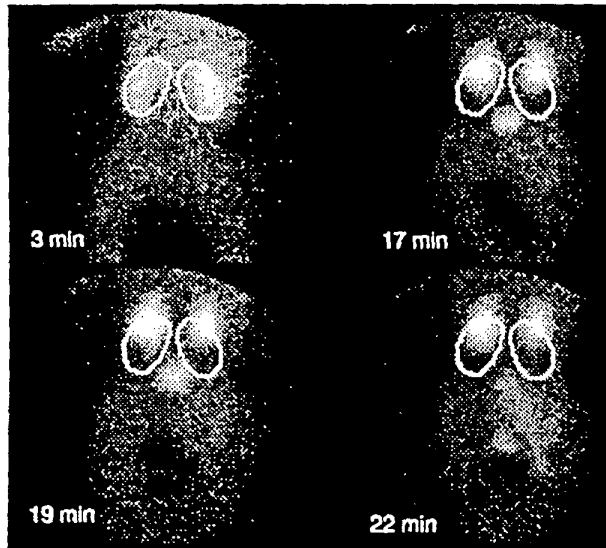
Renal scintigraphic images with superimposed ROIs, showing the effect of patient motion. The ROIs have been selected in the first image of the shown sequence (3min), and are applied to the following images without change of their position.
